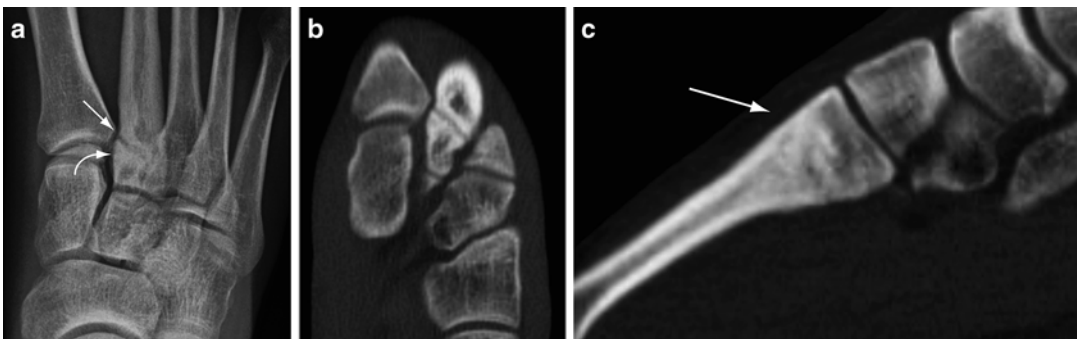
Chronic stress fracture. (a) Frontal radiograph of the foot demonstrates a transverse lucency near the base of the second metatarsal bone (*arrow*). Sclerosis adjacent to the fracture is evident (*curved arrow*). Axial
